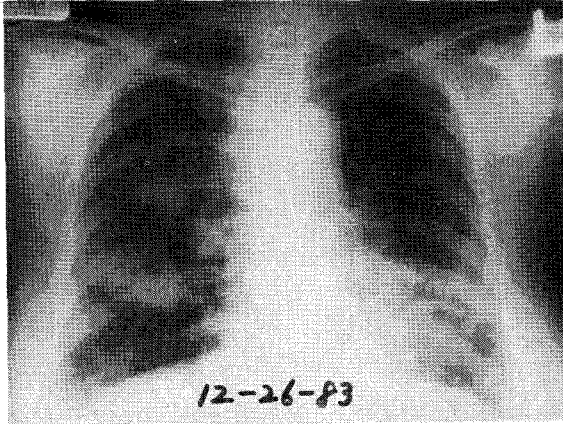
Pre-radiation X-rays of case 2 show multiple variable sized nodular densities throughout both lung fields.
